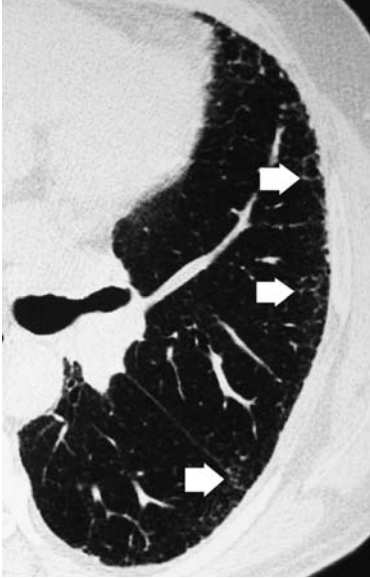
Supine thin-section computed tomography of an individual with asbestosis showing a subpleural reticular pattern due to thickened intralobular structures (*arrows*)
